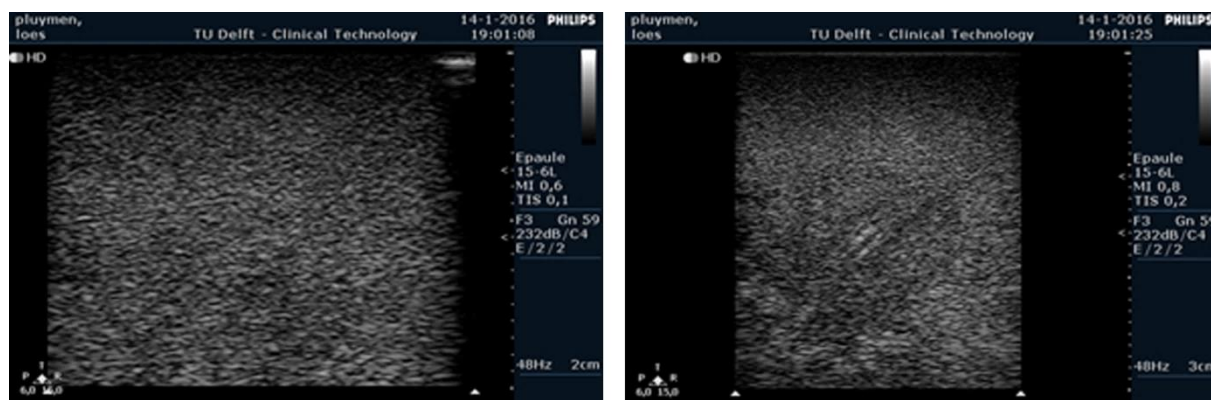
Ultrasound visualization PVA 4% 2FT: 2 images obtained with 2 cm penetration depth
